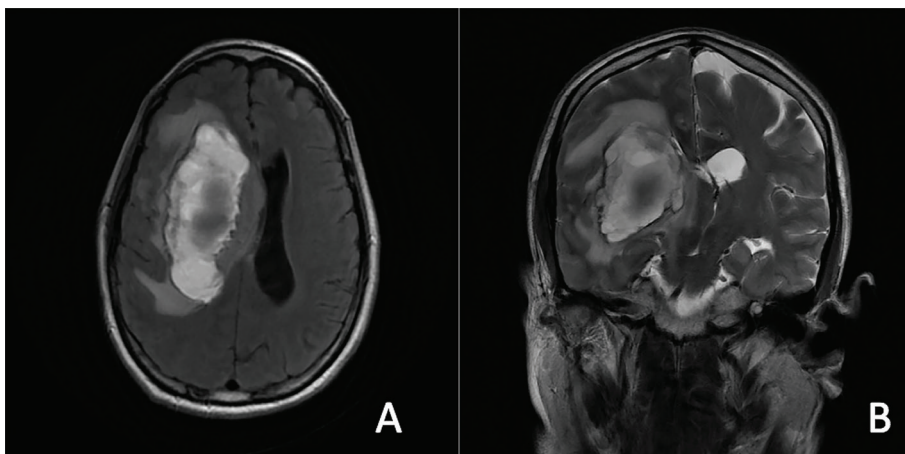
(A and B): Axial and coronal MRI demonstrating right-sided preoperative intracerebral hemorrhage involving the right ventricle.
